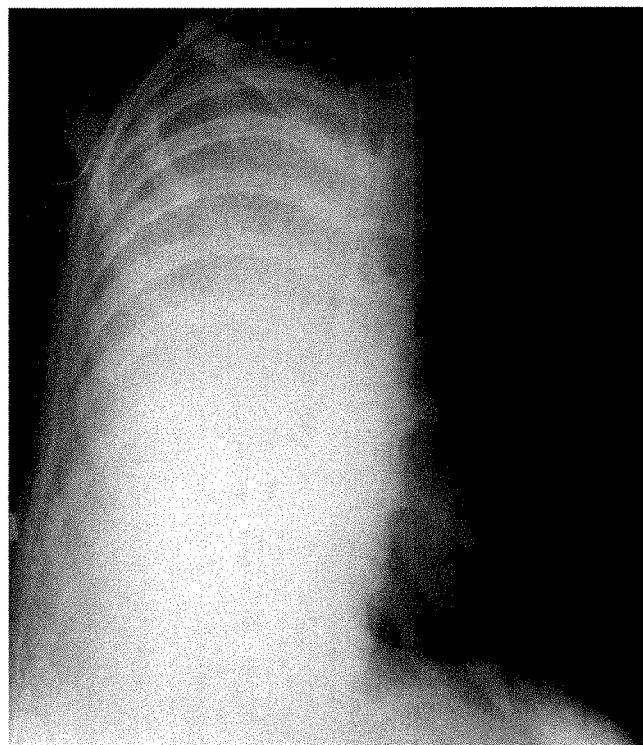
Frontal chest radiograph showing complete opacification of right hemithorax.
